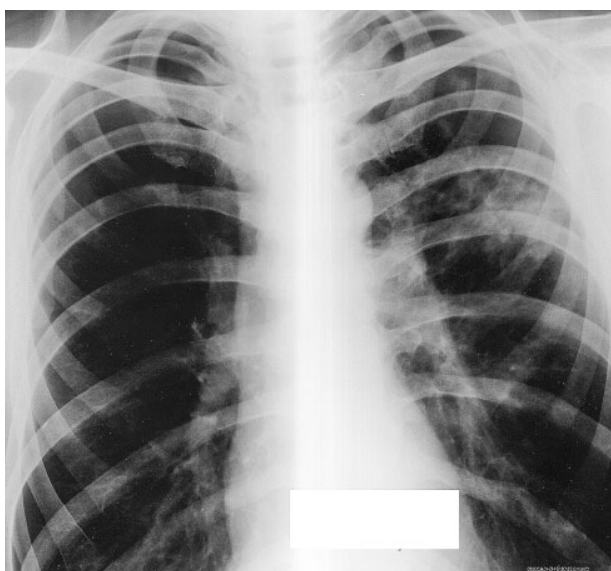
Chest X-ray at the time of patient hospitalisation
